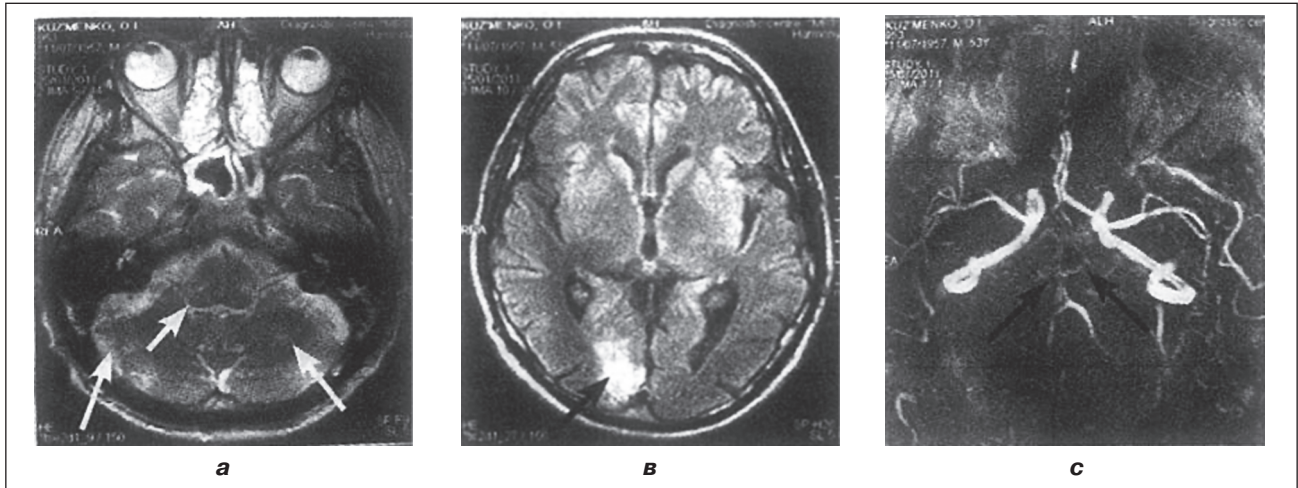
Magnetic resonance imaging of the brain of patient K., 53 years old, T2-weighted image (axial projection). The study was conducted 25 days after the onset of the disease. When compared with the examination from 20 days ago, the sizes of the previously described lesion have decreased, some of them are not even visualized, and the size of the largest lesion in the right occipital region is now $2.3 \times 4.1 \times 1.9$ cm (a, b, arrow); a sharp impoverishment of the vascular pattern of the intracranial main vessels is determined on the MR angiogram (c). Vertebral arteries are narrowed and deformed (c, arrows). The basal artery is also narrowed, its diameter is 0.25 cm (c). Only the initial sections of the posterior cerebral artery are visualized, and the vessels are not identified for the rest of the course
